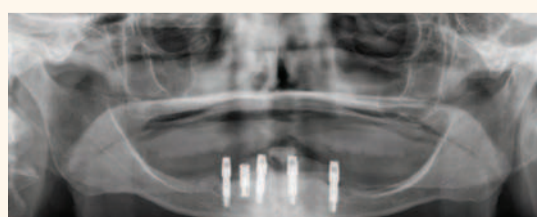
Panoramic radiograph of the abutments seated on the four selected implants. Because the restoration is fully implant-supported, gradual diminution of the residual ridge will present no consequence to the patient
